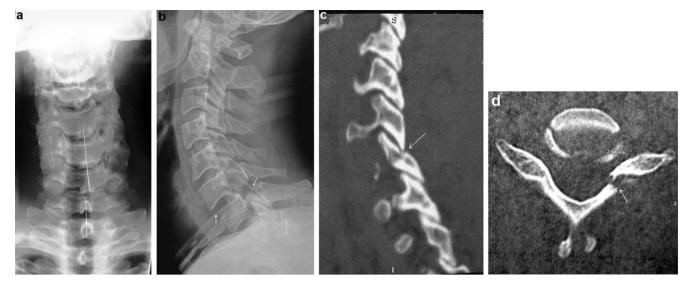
Radiography and CT scanner of the cervical lesion: a: anteroposterior X-ray showing misalignement of C6-C7 spinous processes; b: lateral X-ray with left superior articular facet fracture of C7 with antelisthesis of C6 over C7; c: C7 articular fracture on sagittal CT scan slice; d: axial CT scan slice showing articular fracture with foramen narrowing.
